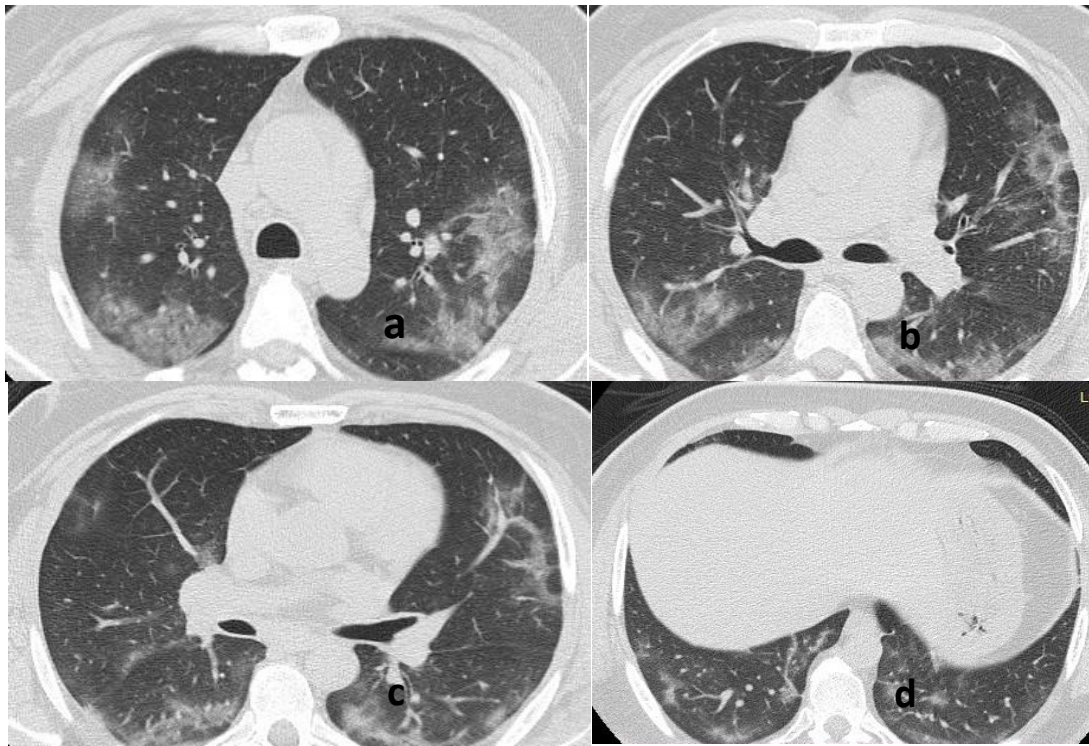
Axial chest CT non contrast images (lung window setting) in male of age 44 yr old who is COVID-19 positive patient. Multiple diffuse areas of ground glass opacities (GGO) with interlobar and interlobular septal thickening (crazy paving pattern) predominantly in peripheral and posterior areas are noted (Images taken 6 days following symptom start) (a- at the carinal region, b- sub carinal region, c-mid basal region and d- basal region)
